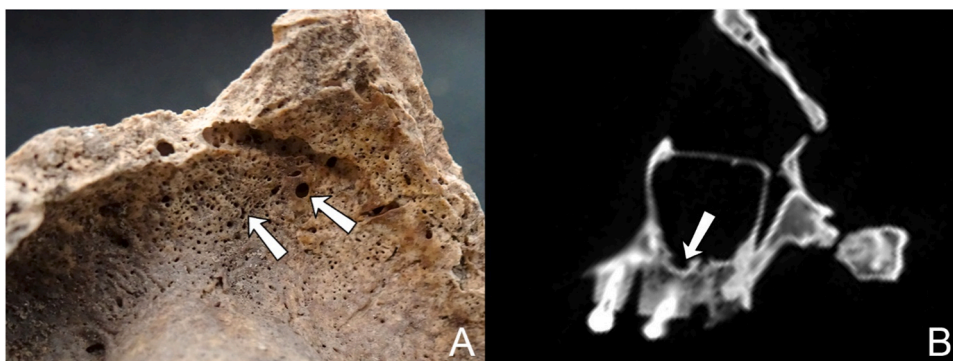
Examples of bone resorption related to chronic maxillary sinusitis adapted from Boocock and colleagues (1995). Lesions are indicated by the white arrows. A) Macroscopic view of broken sinus: bone resorption in the form of pitting of the sinus wall; B) Radiographic view of undamaged, enclosed sinus: bone resorption on the sinus floor.
